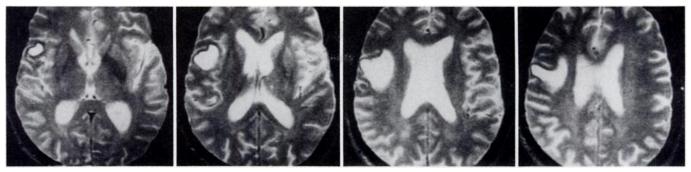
Lobar intracerebral hematoma: amyloid angiopathy. T2-weighted MR images (SE 2,500/80). A prominent mass of hyperintensity (extracellular deoxyhemoglobin) surrounded by a rim of hypointensity (macrophages laden with hemosiderin) in the brain of a 75-year-old patient with mild dementia and acute onset of a focal neurologic deficit is indicative of subacute lobar hematoma.
